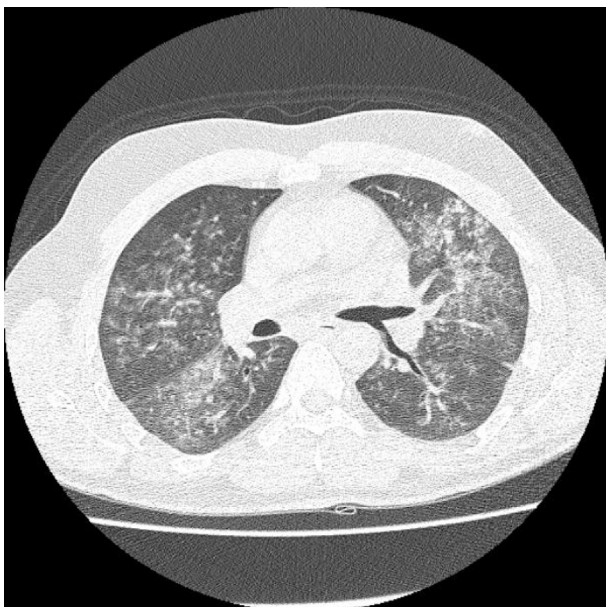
Chest computed tomography showing diffuse ground-glass opacities.
